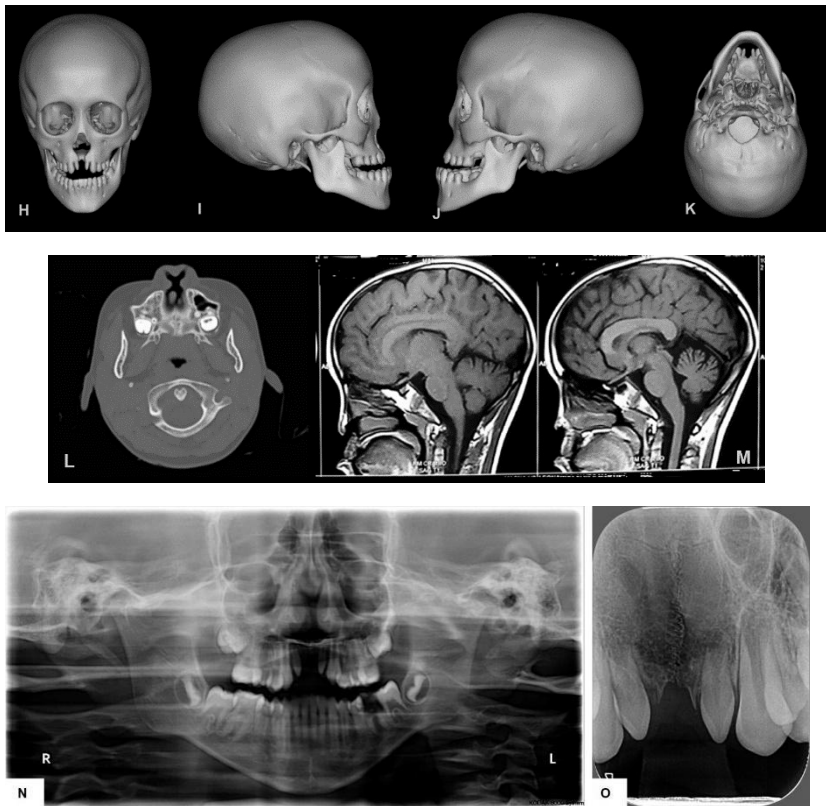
Clinical phenotype of a male patient with holoprosencephaly-like. The facial phenotype is similar to holoprosencephaly except for the absence of an abnormal central nervous system. A-D: at three months old, note an ocular hypotelorism and a flat face with midface hypoplasia, depressed nasal base, absence of the nasal bridge, unique nasal cavity, absence of the columella and philtrum, a wide median cleft lip, and premaxilla agenesis with a V-shape defect in the central region of the maxillary alveolar arch. E-G: postoperative follow-up at nine years old. Observe the orbital hypertelorism and midface hypoplasia with a flat nasal bridge. H-J: computed tomography 3D-reconstructions obtained at nine years old. Note the lateral displacement of the nasal processes of the maxilla, the absence of the vomer and anterior nasal spine, and the absence of premaxilla with a wide midline cleft. Small lateral incisors were present in the mesial region of the maxillary processes. K: bottom view of CT 3D
